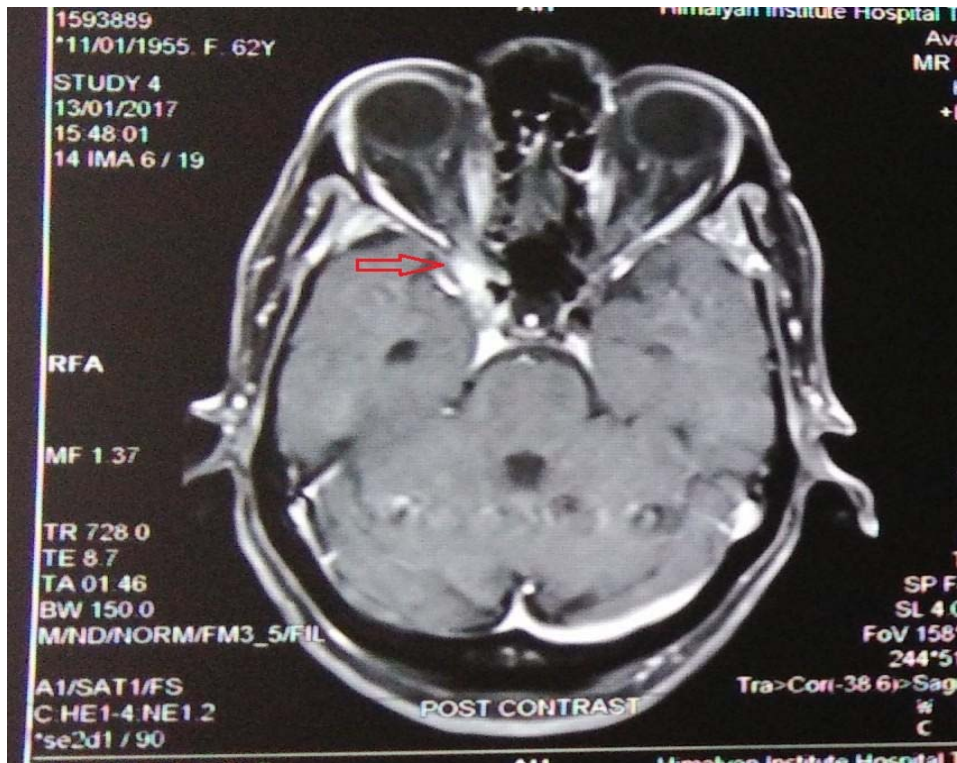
MRI brain showing soft tissue density at right optic foramen.
